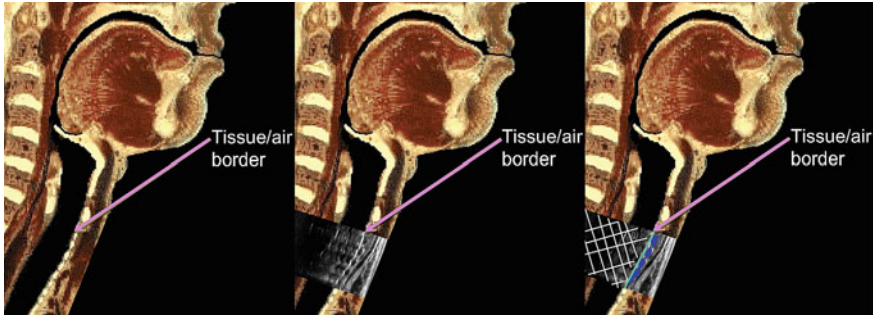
The tissue/air border. Left: A cadaveric slice of the upper airway. The arrow indicates the tissue/air border. Middle: The ultrasonographic image. Right: Explanation of the ultrasonographic image: Blue rings indicate the anterior part of the tracheal rings, The green line is the tissue/air border between the mucosal lining of the anterior trachea and air. The image area covered by the white grid is entirely made up of artifacts (Courtesy The Scandinavian Airway Management Course, Airwaymanagement.dk)
